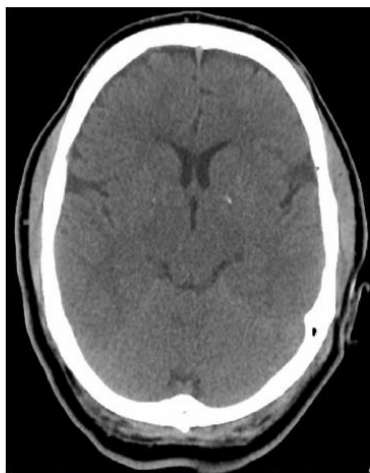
Computed tomography scan of the brain without contrast obtained hours earlier without evidence of globus pallidus ischemia.
